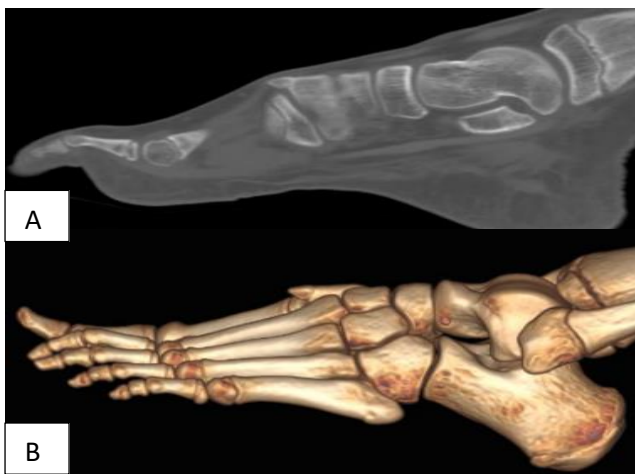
Sagittal CT (A) and sagittal 3D (B) of the extra bone attached to the distal end of medial Cuneiform bone.
